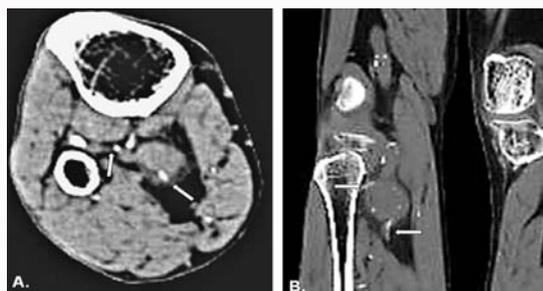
Preoperative Angio-CT imaging: (A) An axial Angio-CT view showing the TPT aneurysm, the ATA origin (upper arrow) and the initial segment of the PTA and the Peroneal artery (lower arrow). (B) Sagittal exploration evincing the same anatomical features at the ATA origin (upper arrow) and the TPT bifurcation (lower arrow).
